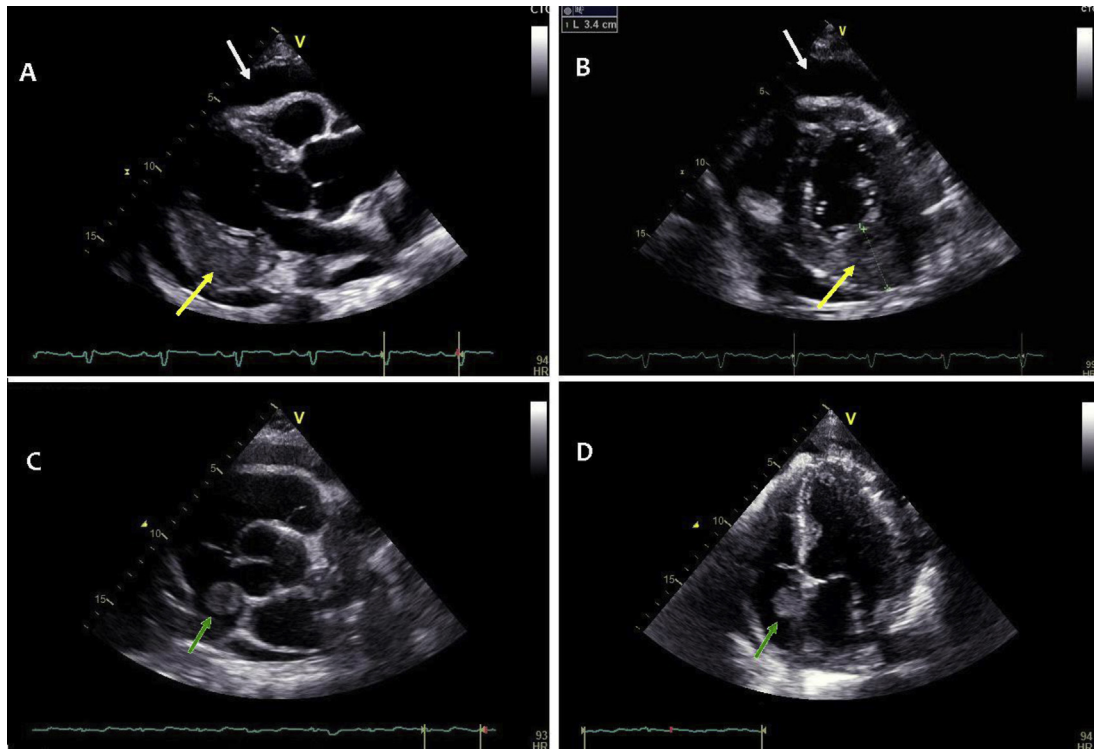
Panels A and B: parasternal view (long and short axis): left ventricular lateral and inferolateral mid and basal wall thickening (3.4 cm; lower arrow); pericardial effusion (upper arrow). Panels C and D: parasternal view (aortic plane) and four-chamber view: round mass protruding on the right side of the interatrial septum (arrow).
